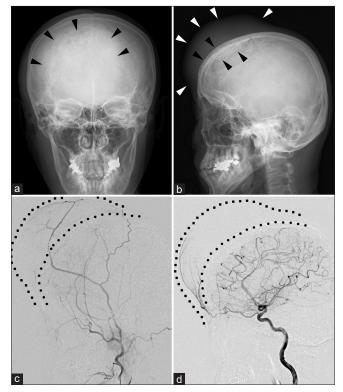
Preoperative X-ray and digital subtraction angiography. (a and b) Skull X-ray. Note mixture of permeative deossification and sclerosis with preserved outline of the skull (black arrowheads) underlying the subcutaneous tumor (white arrowheads). (c and d) Lateral digital subtraction angiography of the right external carotid artery (c) and right internal carotid artery (d). The angiograph shows poor vascularization of the extracranial and intracranial compartments of the tumor from both the external and internal carotid artery circulations. Line of circles: the outer table of the skull; line of squares: the contour of the skin.
